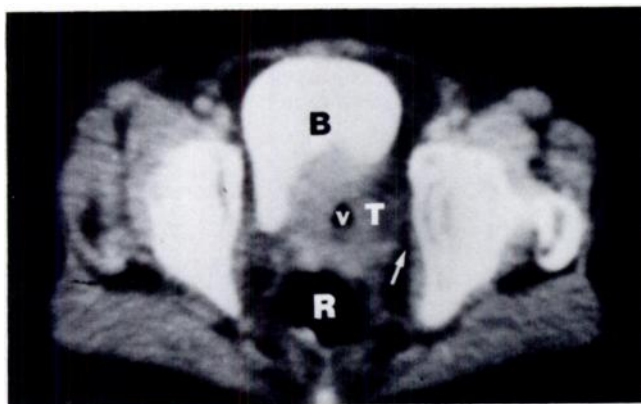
Stage IIB cervix carcinoma. CT scan through rectum (R) and vaginal apex (v). Cervix tumor (T) indents bladder (B) and extends directly to left pelvic sidewall (arrow).
